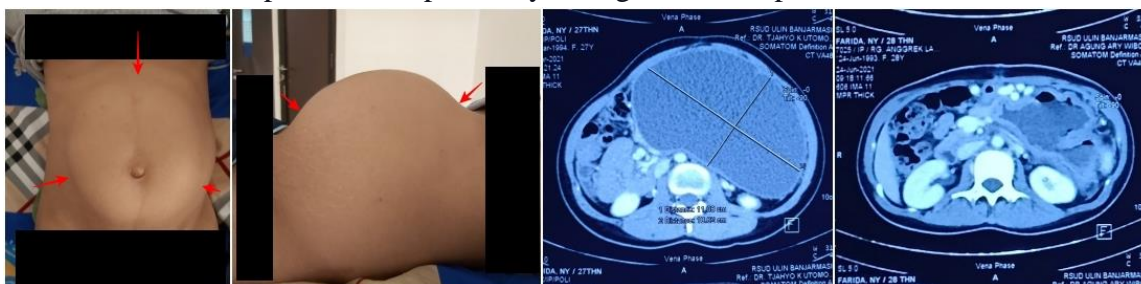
Clinical picture and CT scan before and after the operation of Case 3.
